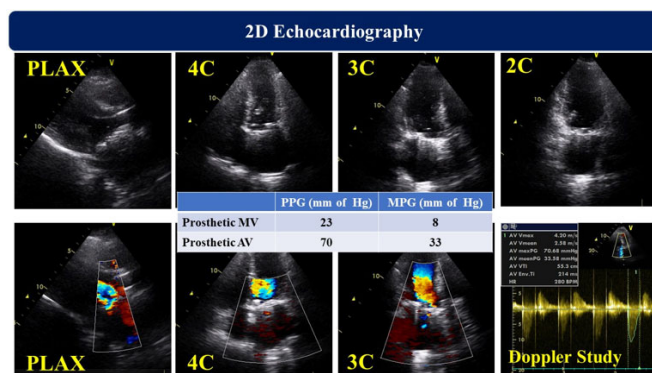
Post DVR 2D Echocardiographic stills.
